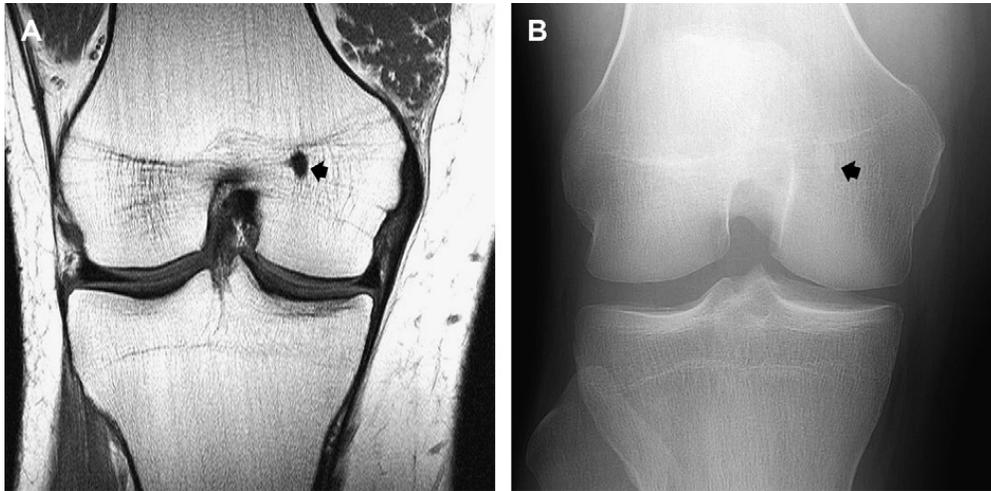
Bone island (enostosis) in the medial femoral epiphysis in a 22-year-old man. (A) Coronal weighted (TR/TE; 704/14) spin-echo MR image of the distal femur shows an oval focus of decreased signal intensity (*arrow*). The lesion blends into the surrounding cancellous bone, yielding a spiculated margin. (B) Anteroposterior radiograph of the distal femur shows a subtle bone island (*arrow*) corresponding to the lesion seen on MR imaging.
